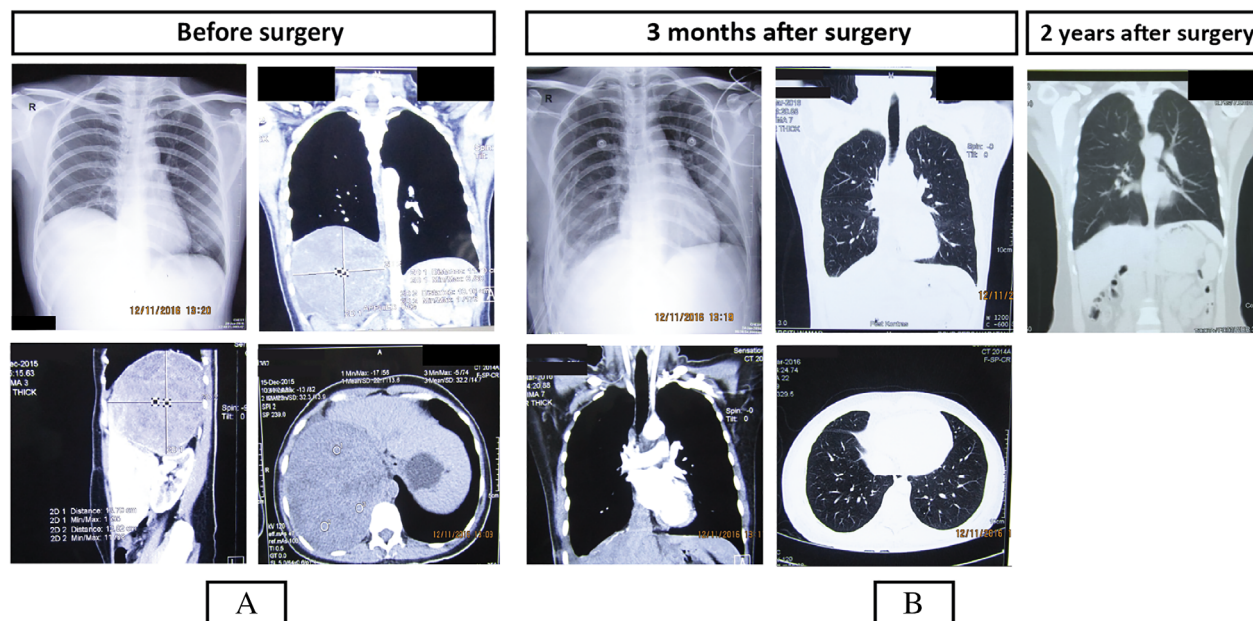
(A) Chest X-ray and thoracic computed tomography (CT) scan with contrast revealed a giant solid mass (12.8 × 11.1 × 13 cm) at the levels of seventh, eighth, ninth, and 10th right lung segments. (B) Chest X-ray and thoracic CT scan three months and two years after surgery.
